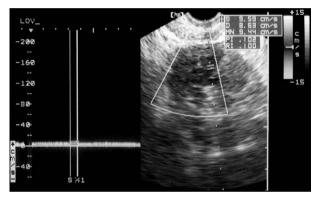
Doppler waveform analysis of the tumor demonstrates low impedance to blood flow (pulsatility index = 0.102; resistance index = 0.100).
